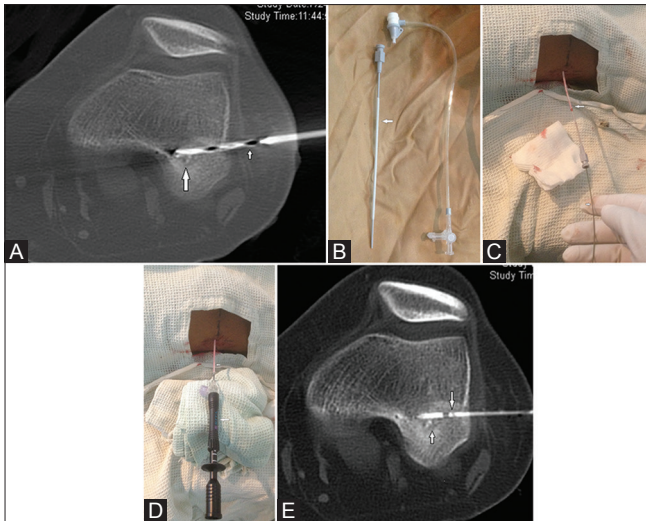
(A-E): (A) Drill bit (small arrow) in the nidus (large arrow) of the OO in lateral condyle of the femur. (B) Vascular access sheath with dilator (arrow) cut and separated from its hub. (C) Vascular access sheath along with dilator (arrow) introduced into the nidus over Amplatz wire (small arrow). (D) RFA probe (large arrow) was introduced through the vascular access sheath (small arrow) into the nidus after removing Amplatz guidewire and dilator. (E) Axial CT image shows RFA probe (large arrow) in the nidus (small arrow) of OO
